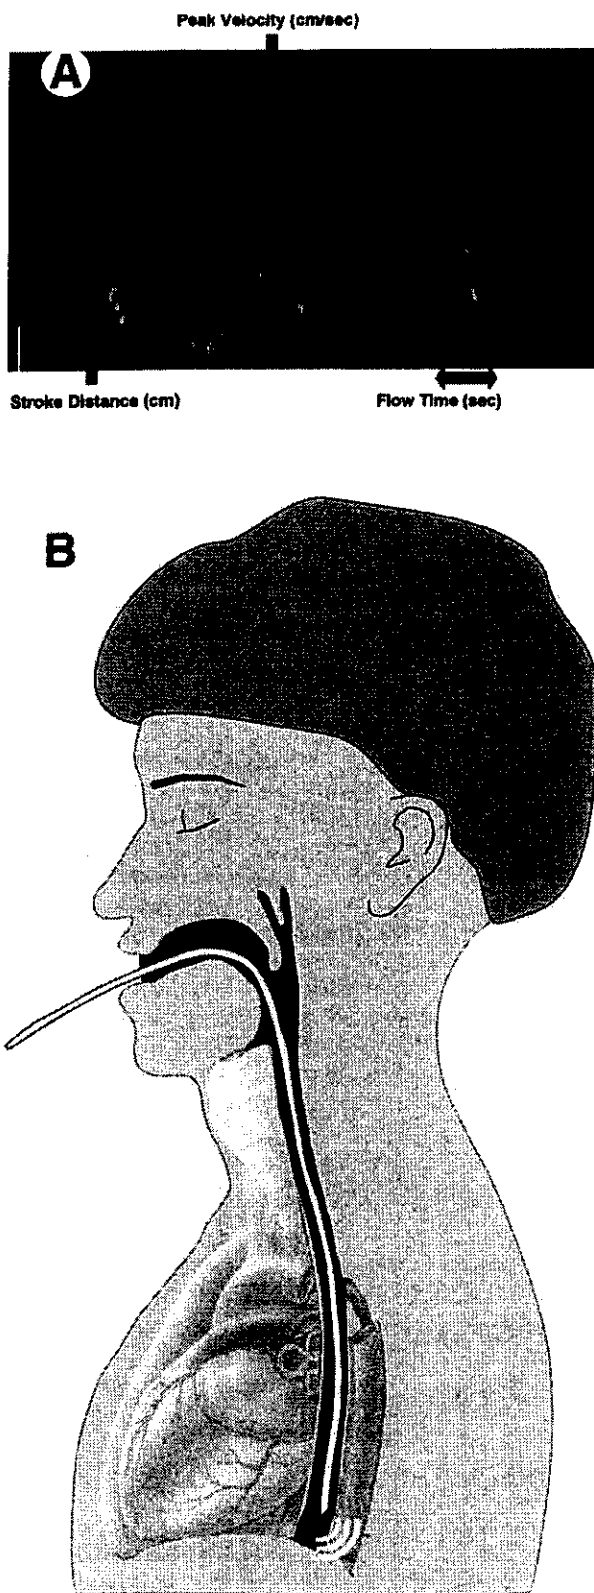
(A) Esophageal Doppler flow-velocity waveform. (B) Doppler measurement of cardiac output. The transducer is located at the tip of an esophageal probe and directed at the descending thoracic aorta.
